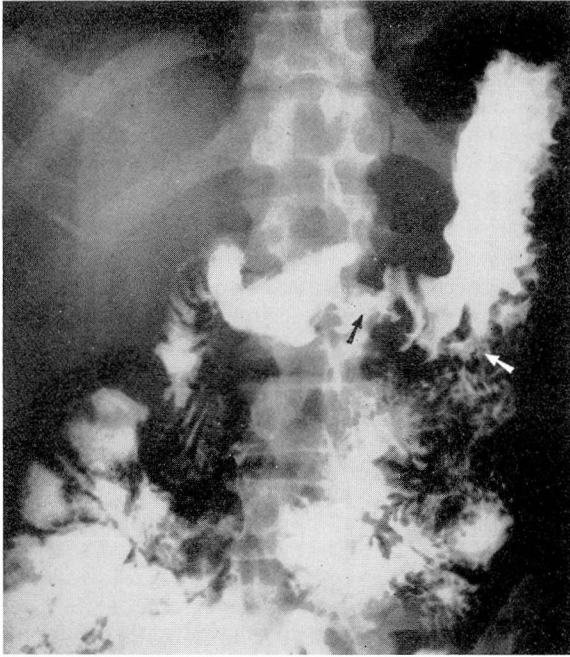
Case 2. Roentgenogram of stomach. Arrow on right shows site of gastroenterostomy; that on left points to a large ulcerating neoplasm in distal portion of stomach.
